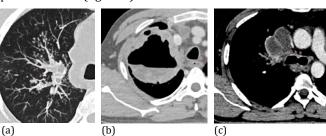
HRCT findings. a). Multiple centrilobular, branching nodular opacities with a "tree-in-bud" appearance b) Thick-walled cavity a right upper lobe with an air-fluid level. c) Enlarged necrotic hilar lymph node.
